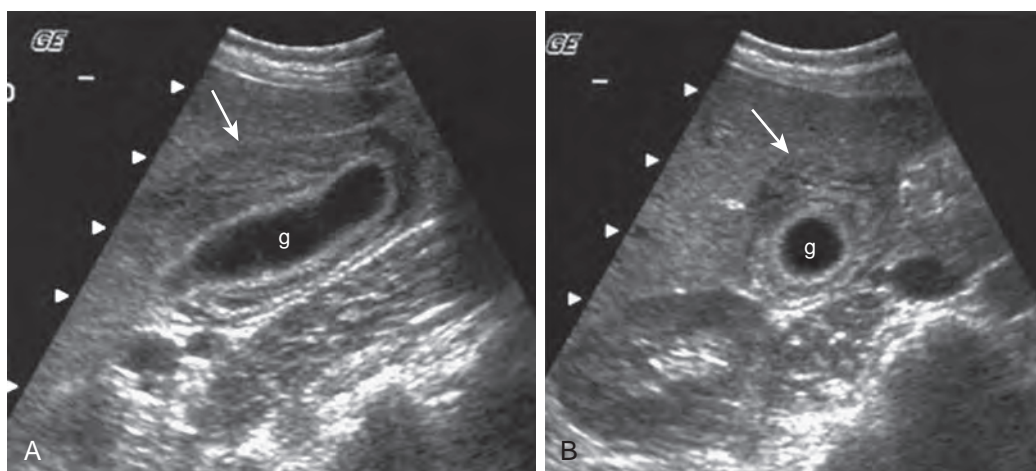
Gallbladder manifestations of acute hepatitis: ultrasound findings. Sagittal (A) and transverse (B) images of the gallbladder demonstrate that the gallbladder lumen (g) is not significantly distended. The wall is markedly thickened (arrows) and has a striated appearance, indicating mural edema.
